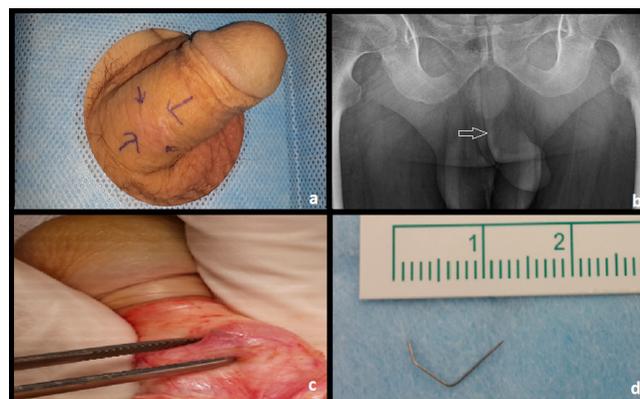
In the right half of the penis, the hyperemic lesion area indicated by the arrows (a); The needle opacity indicated by the arrow in the X-ray imaging (b); Operation image (c); Macroscopic view of the needle (d).
